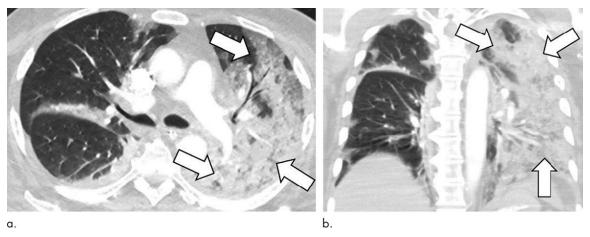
Images in a 74-year-old man with COVID-19 presenting with 7 days of cough. (a) Axial and (b) coronal contrast-enhanced thin-section chest CT images show diffuse ground-glass opacity and consolidation in left lung (arrows). These findings would be classified as indeterminate as per the Radiological Society of North America, British Society of Thoracic Imaging, and COVID-19 structured reporting assessment systems; these findings would be classified as equivocal/unsure as per the COVID-19 Reporting and Data System.
